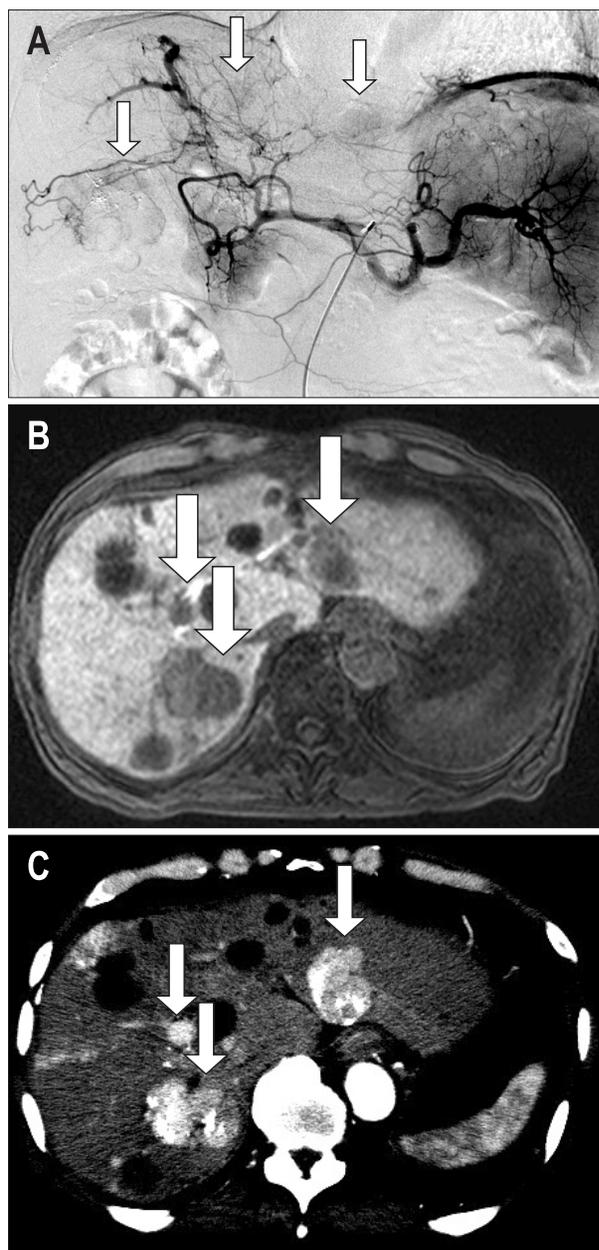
Case 2. An 84-year-old man with unresectable hepatocellular carcinoma (HCC) who received transcatheter arterial chemotherapy with miriplatin. (A) Abdominal angiography showed multiple HCCs (arrows). (B) Magnetic resonance imaging (hepatobiliary phase) showed multiple HCCs (arrows). (C) Computed tomography performed 2 months after transcatheter arterial chemotherapy with miriplatin. The lesions showed accumulations of lipiodol (arrows). The treatment efficacy was assessed as a stable disease.
